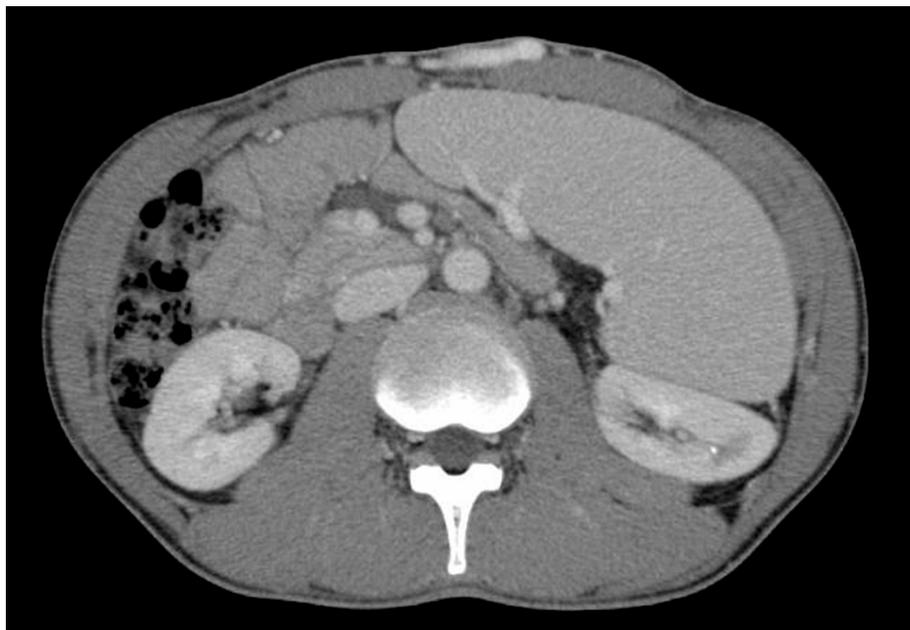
Abdominal contrast CT showing severe splenomegaly measuring 15 cm and venous dilation in the abdominal wall.
